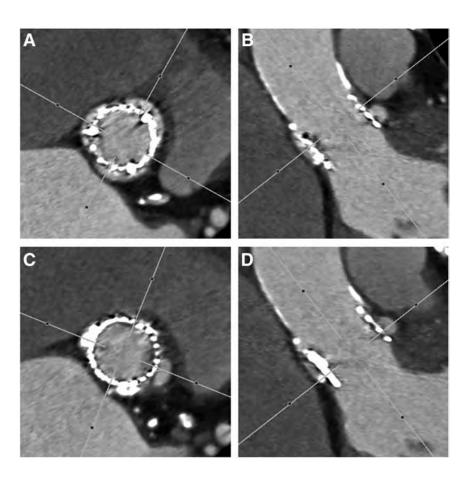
An 84-year-old female patient with status post-TAVI and contained rupture on follow-up multislice computed tomography in close anatomic relation to the left aortic sinus. A, the double-oblique transverse view at the level of the native aortic sinus, (B) the coronal-oblique view through the aortic root (red line indicates level of A), (C) the double-oblique transverse view at the level of the pseudoaneuryms, (D) coronal-oblique view through the aortic root (red line indicates level of C). Relative increase in calculated average annulus diameter was 15.6%. TAVI indicates transcatheter aortic valve implantation.
